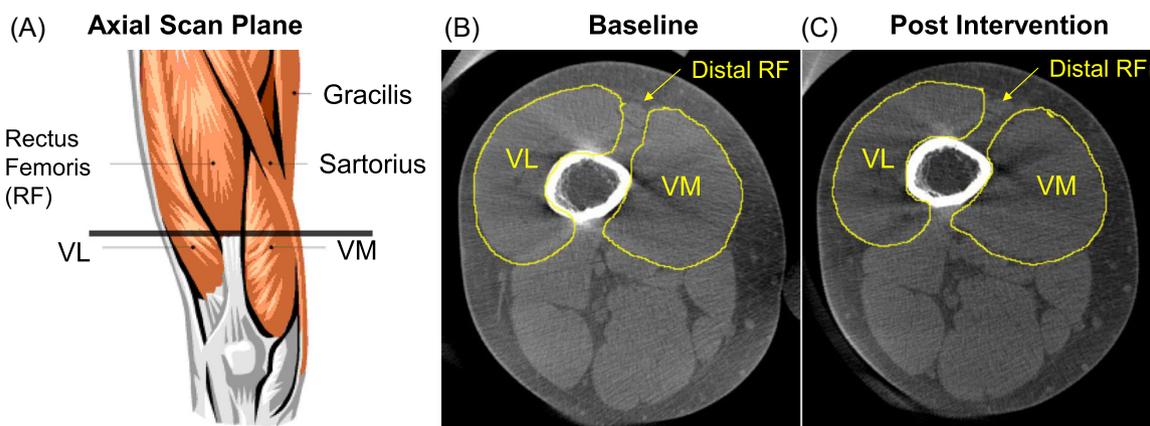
Measurement of VL:VM cross-sectional area ratio from CT images targeting the quadriceps muscles while a participant was positioned in a supine, nonweight-bearing condition with the knees at full extension. (A) An axial scan plane (dashed line) corresponding to the level of the distal appearance of the rectus femoris muscle was chosen. The VL and VM cross-sectional areas were manually outlined, and VL:VM ratio was calculated (B) at baseline and (C) after the BoNT-A and 6-week home exercise program. BoNT-A, botulinum neurotoxin type A; CT, computed tomography; VL, vastus lateralis; VM, vastus medialis.
